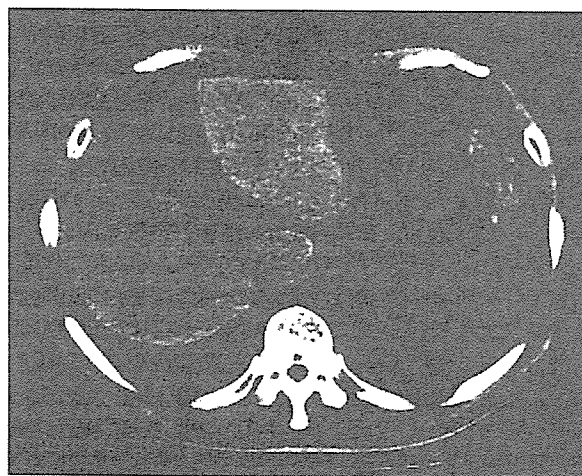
Upper abdominal computed tomography. The cystic lesion disappeared after drainage and monoethanolamine oleate treatment.
